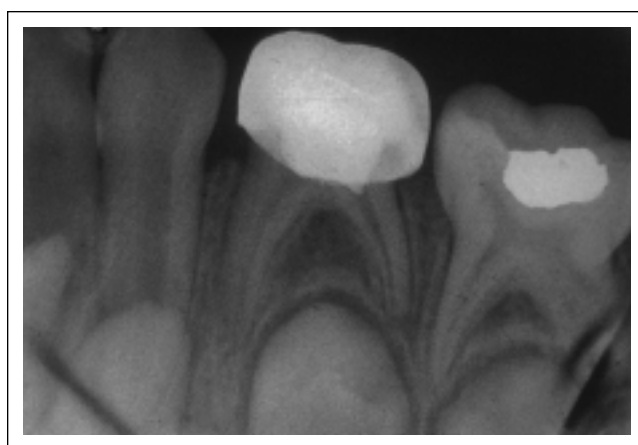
Radiograph of same tooth at the day of pulpotomy.
